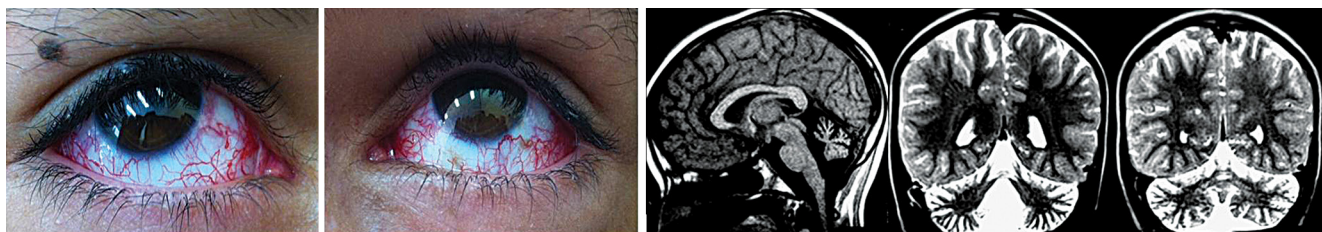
Nine year-old boy who presented gait difficulties since age two-years-old. Left figures: bilateral ocular telangiectasias. Right figures: MRI (sagittal T1 and coronal T2) images showing cerebellar atrophy.
